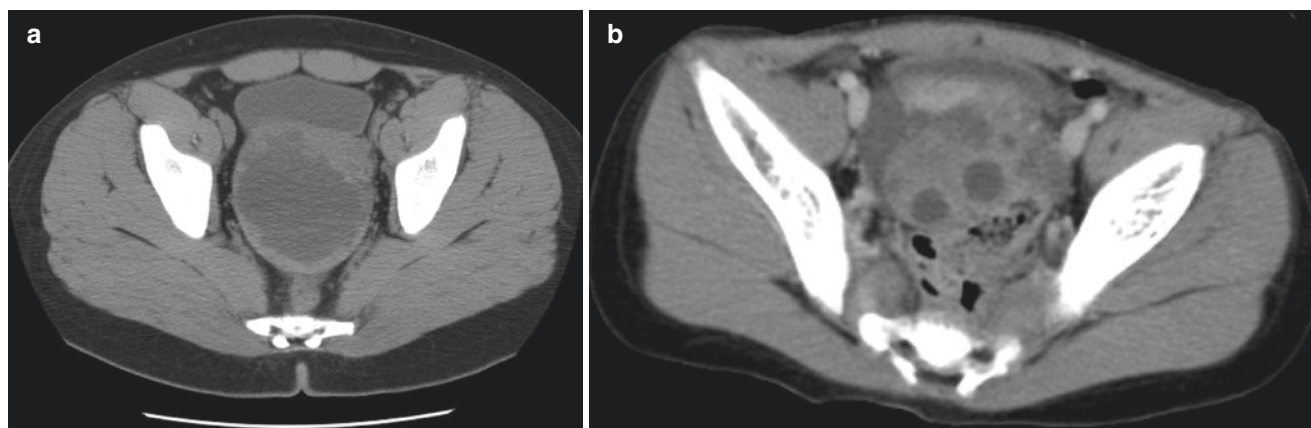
14 year old girl with severe abdominal pain secondary to ovarian torsion (a) axial post contrast CT shows a large necrotic mass in the pelvis (b) inferior image through the pelvis demonstrates the peripheral cysts typical for ovarian torsion
